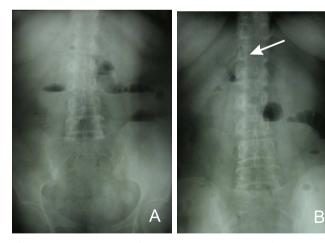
A: X-ray of the abdomen showing air-fluid levels. B: presence of air in the bile ducts.
